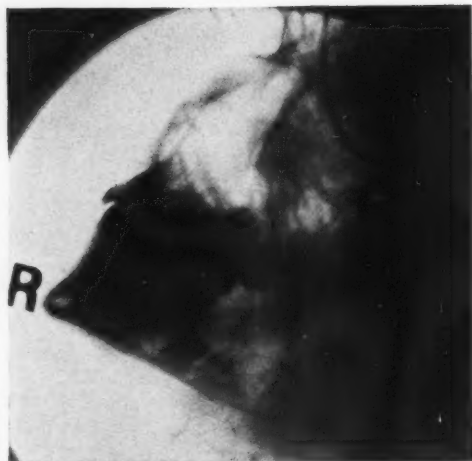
Roentgenogram of a giant-cell tumor at the angle of the lower jaw. The patient's age is 12, hence the unerupted teeth. Path. No. 36,750.
